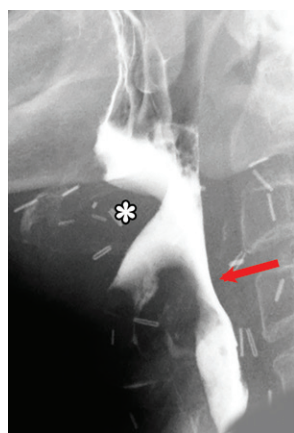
Insufficient closure of the laryngeal lumen during swallowing in a 69-year-old woman. Lateral radiograph of the pharynx during swallowing shows an opened laryngeal vestibule with penetration of contrast material. Additional findings are deformity of the epiglottis (*), poor pharyngeal contractions, and a stricture of the PES (arrow) due to chemotherapy and radiation therapy.
